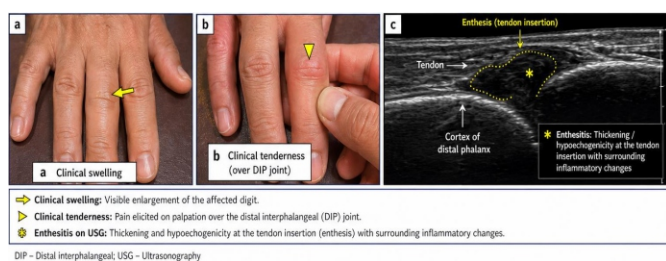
Ultrasound Features of DIP Joint Enthesitis Showing Clinical Tenderness, Clinical Swelling, and Enthesitis
